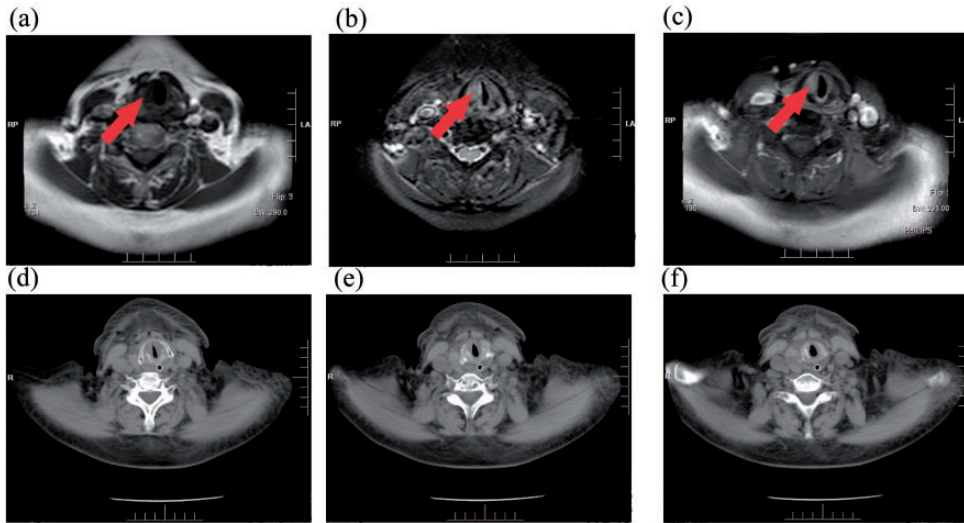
(a–c) MRI showed that the soft tissue shadow of the right side of the vocal cord mucosa of the larynx was significantly thickened. (d–f) CT imaging showed that the right-side sound band was slightly thickened, with reduced soft tissue shadow thickness.
